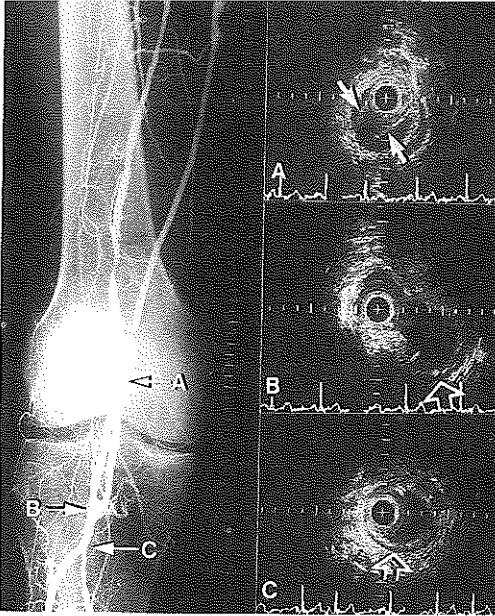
Angiogram after intervention revealing a patent vein bypass graft anastomosis. Intravascular ultrasound images (A–C) correspond to positions indicated on the angiogram. A, the vein is recognised as a homogeneous vessel wall. Valves of the vein (arrows) are visualised as straight echogenic lines. B, the anastomosis is seen to be patent. Note that at this junction the muscular nature of the popliteal artery is characterised by a hypochoic media (open arrow). C, more distally a patent popliteal artery displays a three-layered arterial wall (open arrow). Calibration = 1 mm.
